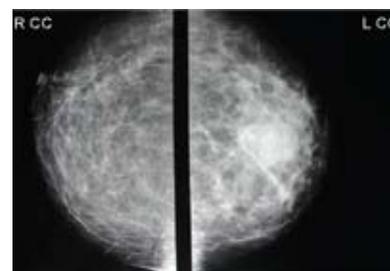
Mammography (x-ray images of right and left breasts).
